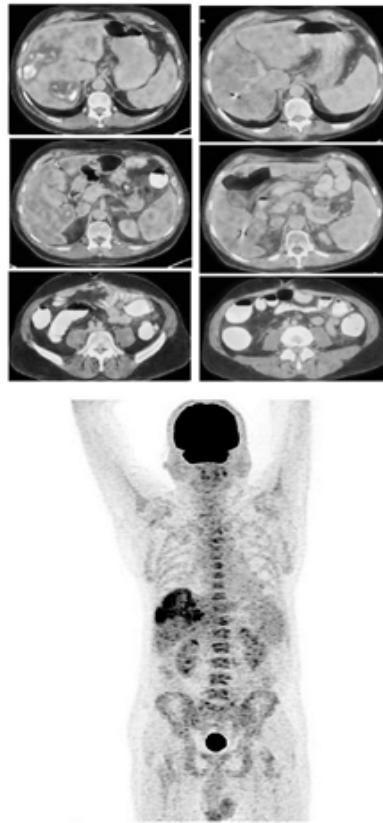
Comparative PET CT Scan of transverse colon. The images to the left showed recurrence in the liver and images to the right show that there was no evidence of anastomotic recurrence and stable necrotic hepatic metastases
